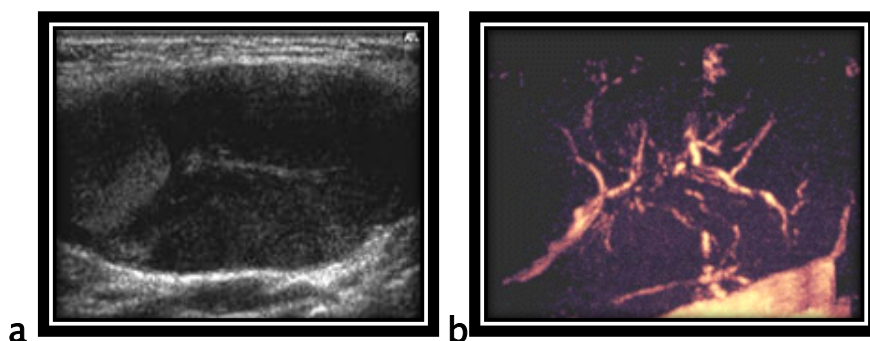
HD of the cervical lymph nodes in a 21-year-old girl. (a) US scan shows lymphomatous infiltration of a cervical lymph node, which appears enlarged, non homogeneous, and partially hyperechoic. (b) Three-dimensional power Doppler US scan of the same lymph node shows distorted vascular branching and vessel amputation (*Toma et al., 2007*).
